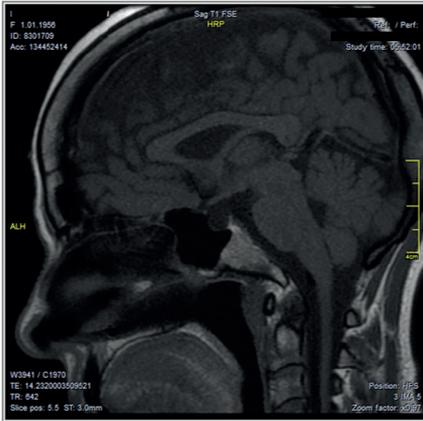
The sagittal T1 weighted magnetic resonance imaging of the brain shows an empty sella turcica
